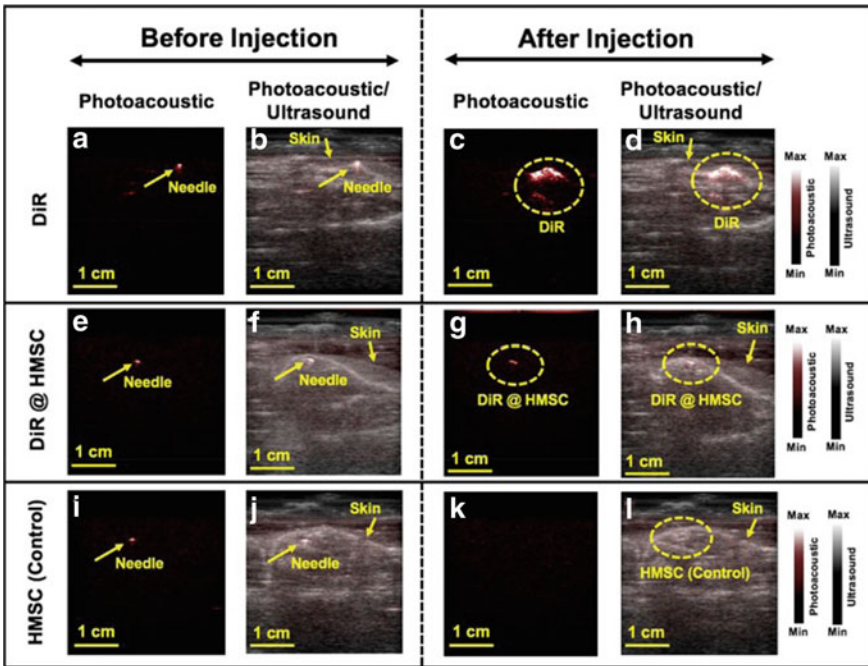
In vivo evaluation of LED-PAUS system. a Photoacoustic image when needle is subcutaneously injected on spinal cord area before DiR injection. The needle has strong photoacoustic signal. b Photoacoustic/ultrasound image of (a). c Photoacoustic image after subcutaneously injection of DiR. d B-mode photoacoustic/ultrasound image of (c). e Photoacoustic image when needle is subcutaneously placed on the spinal cord area before HMSC labeled with DiR (DiR @ HMSC) injection. f B-mode photoacoustic/ultrasound image of (e). g Photoacoustic image after injection of HMSC labeled with DiR (DiR @ HMSC) on spinal cord. h B-mode photoacoustic/ultrasound image of (g). i Photoacoustic image in presence of needle before injection of unlabeled HMSC as control experiment. j B-mode photoacoustic/ultrasound image of (i). k Photoacoustic image of HMSC as control. This image shows no photoacoustic signal for HMSC. l B-mode photoacoustic/ultrasound image of (k). [Reprinted with permission from 24]
